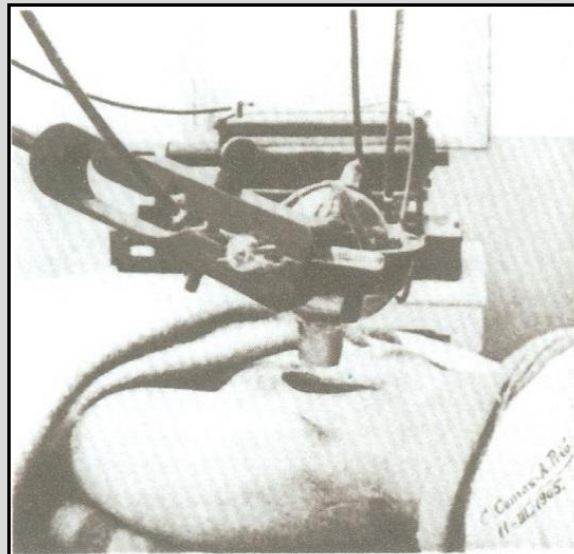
Photographic document of the case report during roentgen treatment. Notice in the right-lower corner of the figure the note with the picture date: 11th March, 1905.
